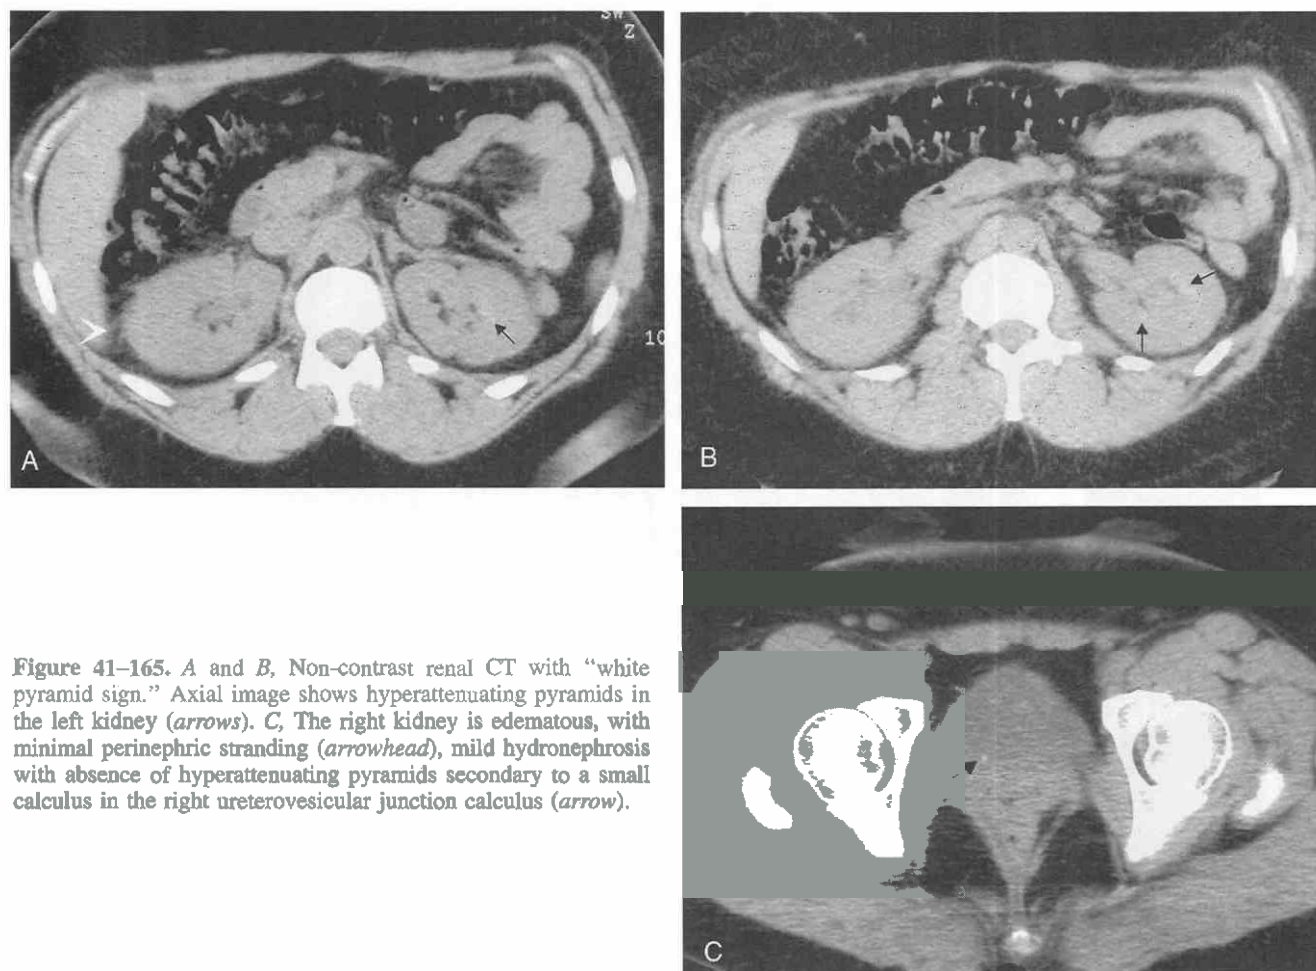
A and B, Non-contrast renal CT with “white pyramid sign.” Axial image shows hyperattenuating pyramids in the left kidney (arrows). C, The right kidney is edematous, with minimal perinephric stranding (arrowhead), mild hydronephrosis with absence of hyperattenuating pyramids secondary to a small calculus in the right ureterovesicular junction calculus (arrow).
